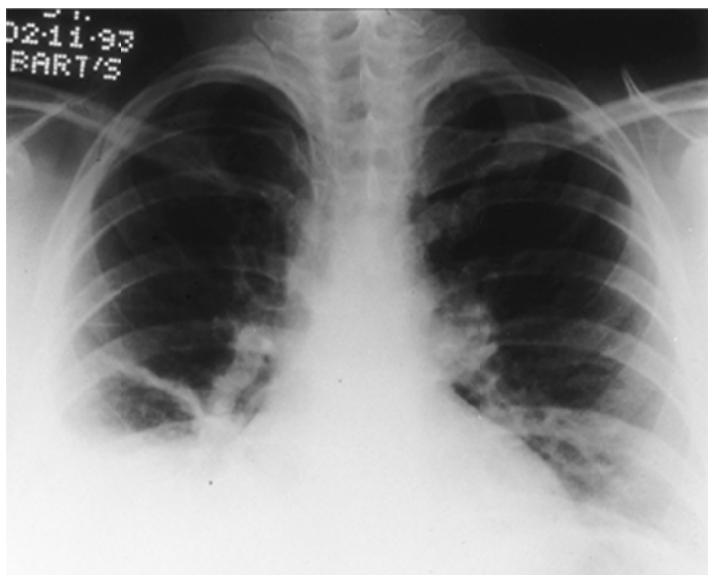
Chest radiograph showing raised right hemidiaphragm and a linear atelectasis in the right midzone.
